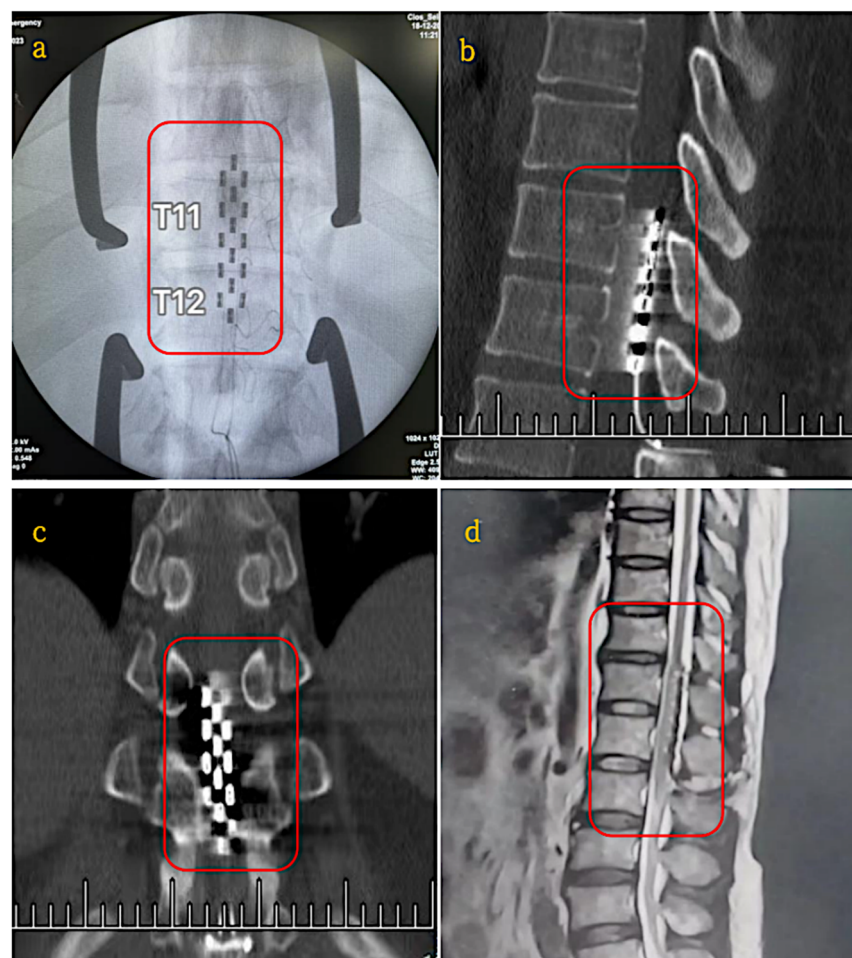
(a) X-ray positioning during surgery for a T11-T12 implantation. Image shows a postoperative CT scan in the sagittal, (b) a CT scan of the coronal, (c) and a CT of the general view. (d) MRI scan of the sagittal view performed after the surgery. The red square shows the site of injury in each image, which is the focal point for analysis in this data [24].
